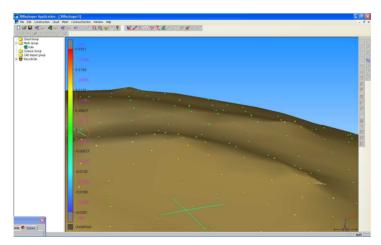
Wavy surface on the 3D model in the vicinity of the pole CT.
